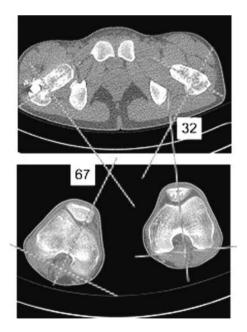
CT assessment of the rotational alignment using the method described by Jeanmart.
